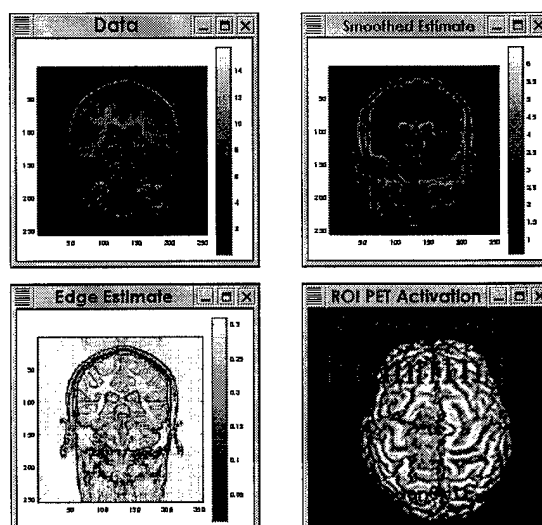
(Top left), Data. (Top right), Smoothed estimate error standard deviations. (Bottom left), Edge estimate error standard deviations. (Bottom right), Brain activation using MRI data to define ROI's from PET volumetric data. Yellow defines tumor volume.
